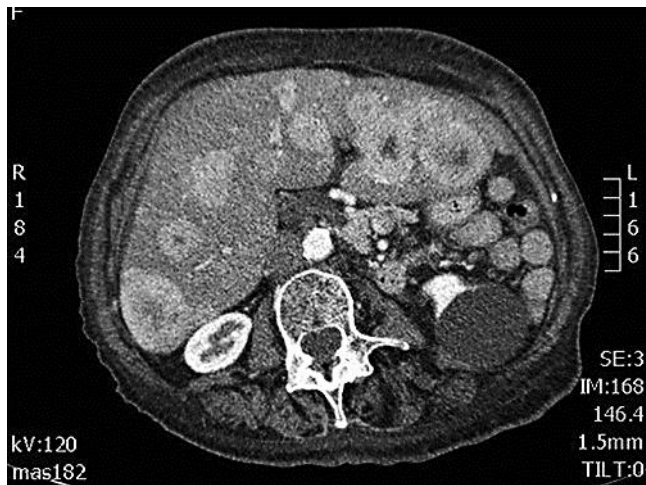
CT scan image showing a mass of 8 × 5 cm in the hilar area of the liver, involving the pancreas head and encasing regional blood vessels.
